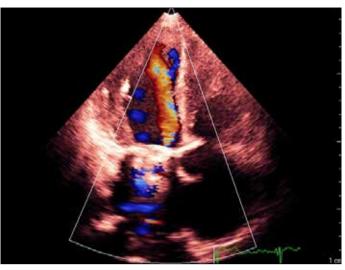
Transthoracic echocardiographic image of the stuck prosthetic mitral valve
